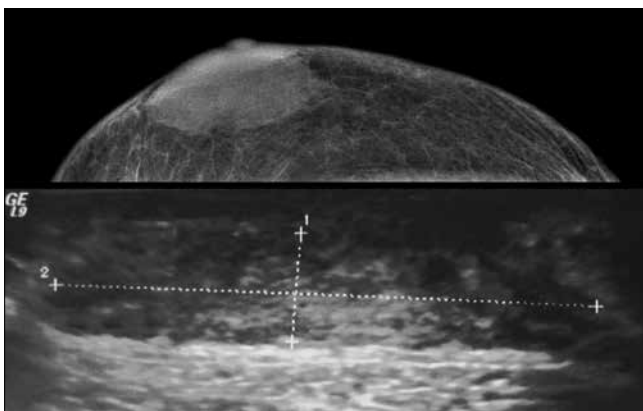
Pathologically proven nodular gynecomastia. Ultrasound demonstrates well-defined discoid area
